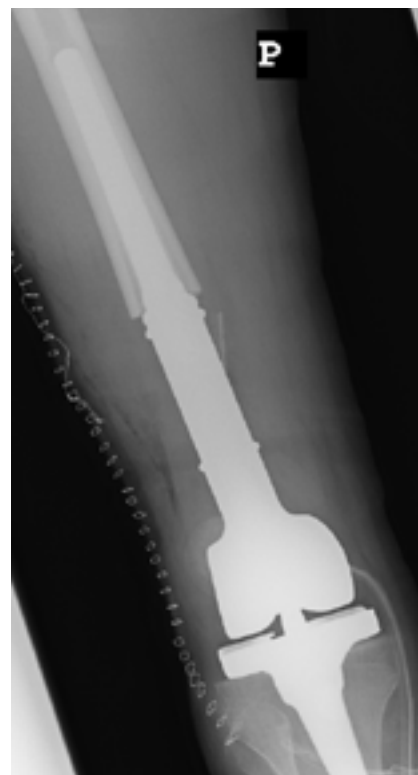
Anteroposterior radiograph of the right knee joint after tumor resection and implantation of a femoral endoprosthesis with a knee joint – postoperative imaging
